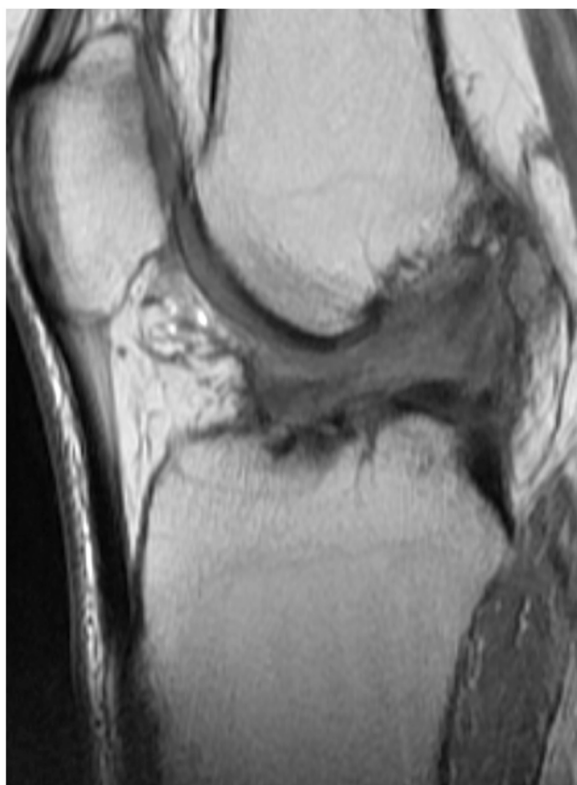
Both grafts invisible in sagittal proton-density magnetic resonance imaging.
